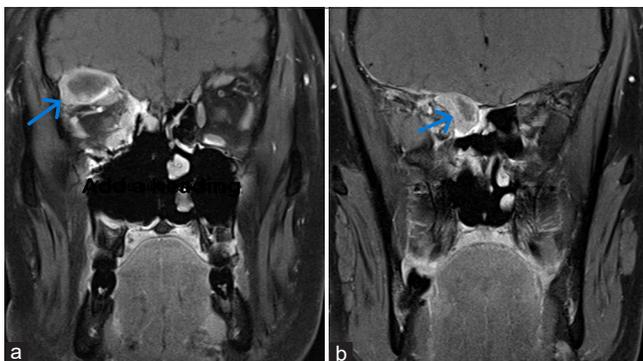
(a-b) Post-contrast T1-weighted coronal image showing heterogeneously enhancing mass lesion, the blue arrow shows invasion of (a) intraorbital extraconal compartment of right orbit and (b) right posterior ethmoidal air cells.
